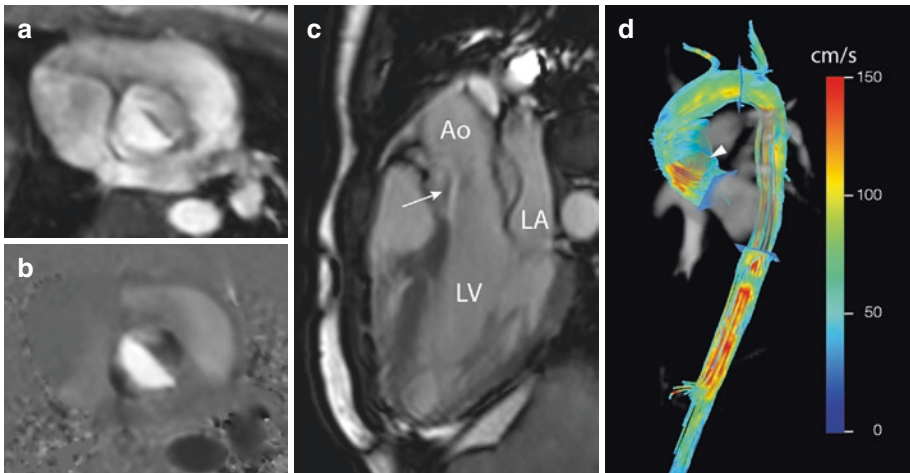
Bicuspid aortic valve. 28-year-old male patient with bicuspid aortic valve and mild dilatation of the ascending aorta. Axial views of through-plane velocity-encoded phase-contrast MRI acquisition of the flow velocity through the valve ((a) magnitude image, (b) phase image). In (c) a double-oblique lateral view of the aortic outflow tract with the bicuspid aortic valve is presented
